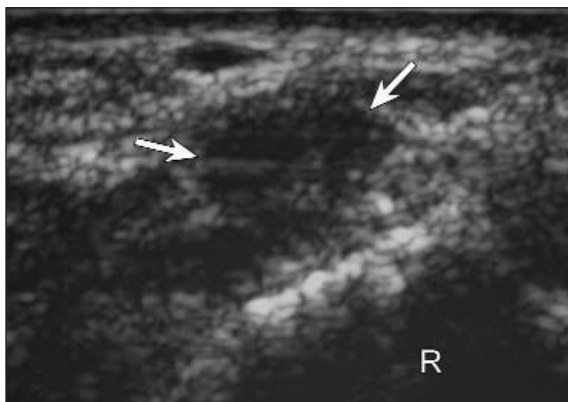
Volar ganglion cyst in a 29-year-old woman. Sagittal sonography shows a 7-mm hypoechoic ganglion cyst (arrows) without posterior acoustic enhancement. Note the poorly defined margins and radiocarpal joint extension (arrowhead). FCR indicates flexor carpi radialis tendon; R, radius; and S, scaphoid.
